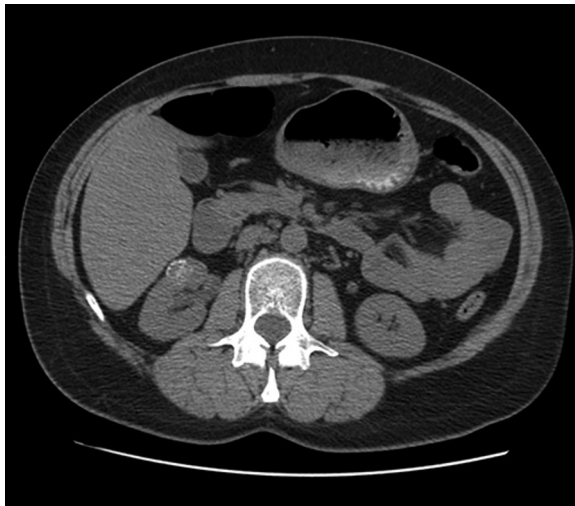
Right renal mass is present containing calcifications (CT without contrast, 2010).
